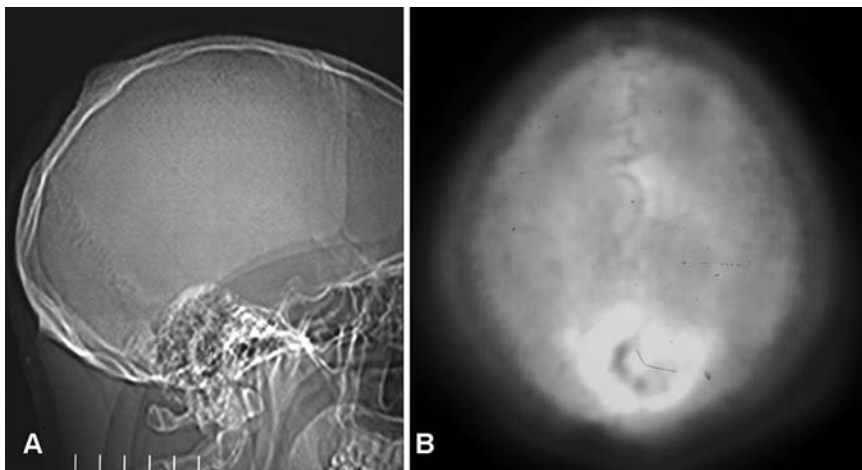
(A) Cranial radiograph demonstrating a lytic lesion. (B) Axial computed tomography scan demonstrating an intra-diploic lytic lesion
